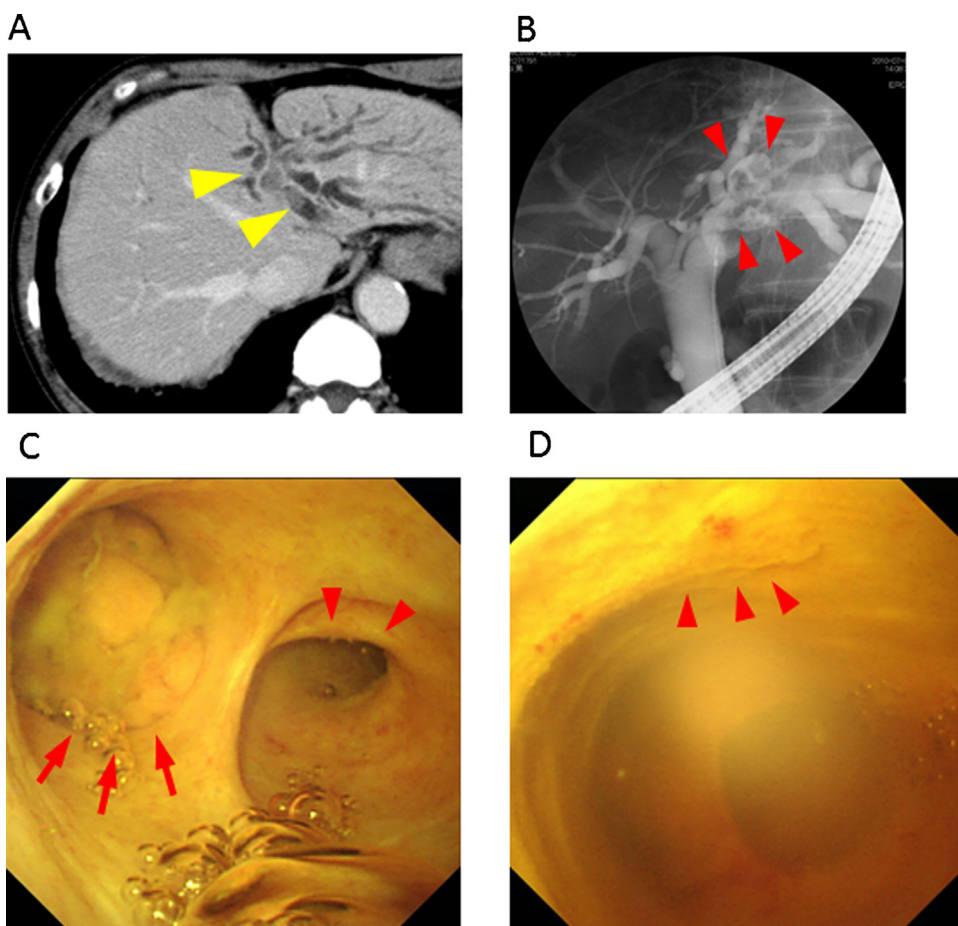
Preoperative imaging studies: (A) Contrast-enhanced computed tomography (CE-CT): Arrowheads show solid lesions in the left hepatic duct. (B) Endoscopic retrograde cholangiography (ERC): Arrowheads indicate filling defects in the left hepatic duct. (C–D) Peroral cholangioscopy: (C) Arrowheads indicate the orifice of the right hepatic duct. No tumor lesions are presented. Arrows indicate the orifice of the left hepatic duct which is completely filled with papillary tumors. (D) Arrowheads indicate papillary tumors located in the common hepatic duct.
